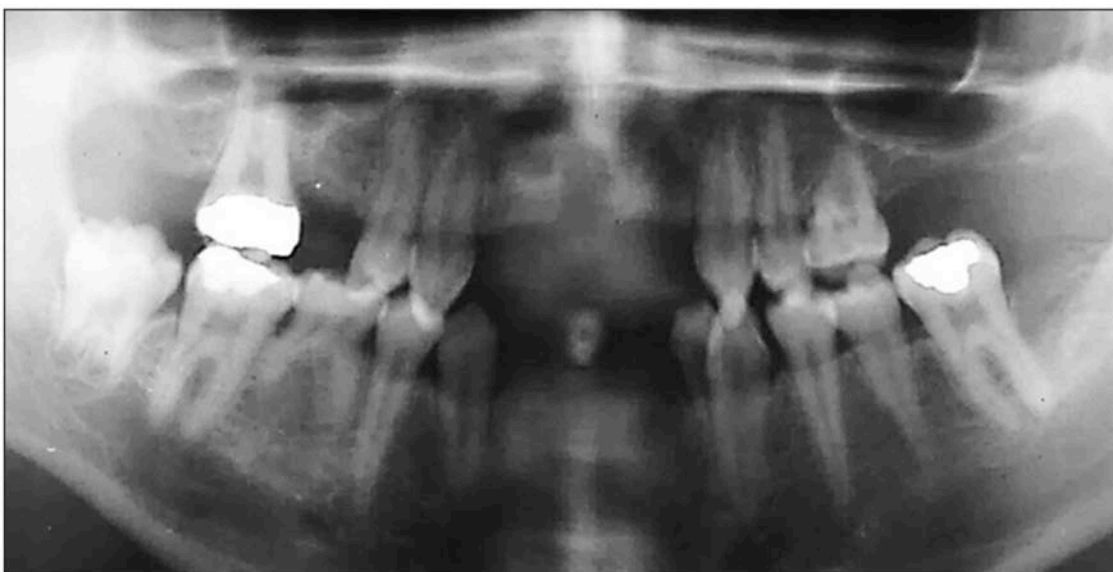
Cropped panoramic radiograph of child patient with ectodermal dysplasia.
